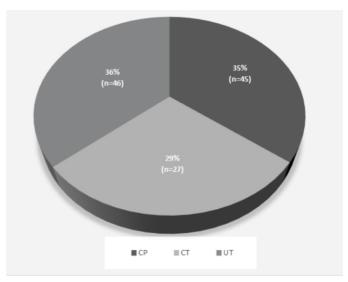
Prevalence of Smoking among different Categories of Prisoners: Condemned Prisoner (CP), Convicted Prisoner (CT), Under Trial Prisoners (UT)
